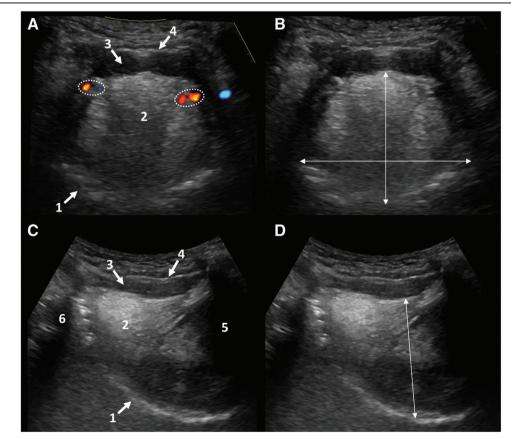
Ultrasonographic measurement of tongue base and mid-tongue width and height. A, Lingual arteries were seen with color flow Doppler (dotted ellipses) on both sides of lower lateral borders of tongue base, where they entered tongue base inferiorly. Also seen were (1) mucosal covering of tongue, (2) genioglossus muscle, (3) geniohyoid muscle, and (4) mylohyoid muscle. B, Maximal width and height of tongue base. C, (1) Mucosal covering of tongue, (2) genioglossus muscle, (3) geniohyoid muscle, (4) mylohyoid muscle, and acoustic shadows reflecting (5) body of mandible, and (6) hyoid bone. D, Maximal height of mid-tongue.
